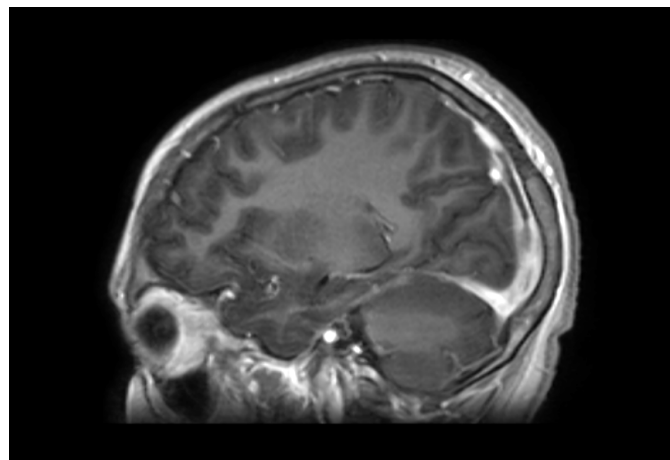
MRI of the brain showing thrombosis of posterior aspect of superior sagittal sinus and left transverse sinus
